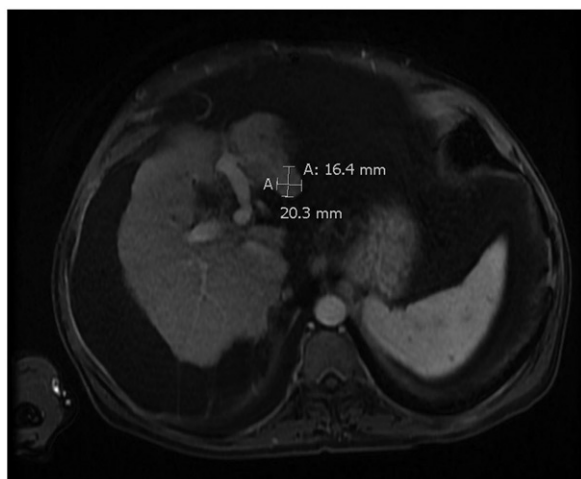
Axial T1 contrast-enhanced MRI showing nodular liver with residual tumor.
